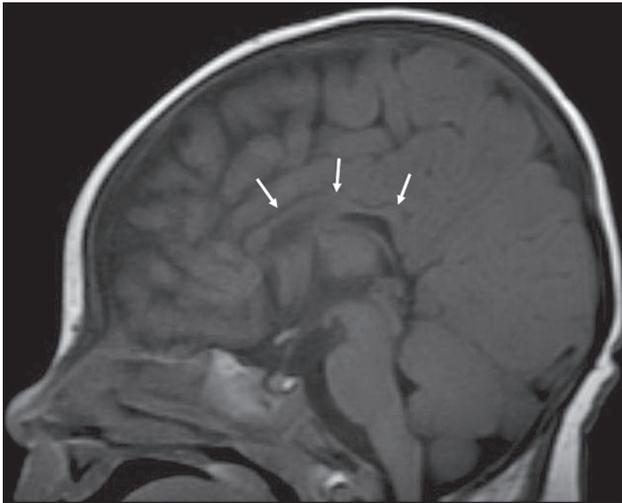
Sagittal T1 brain MRI showing thinning of the corpus callosum and absent rostrum.
